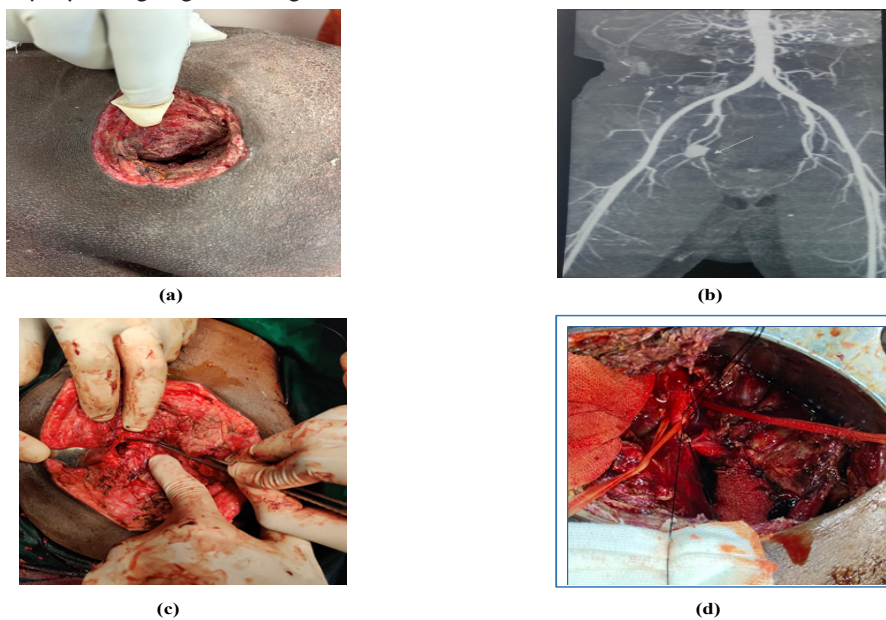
(a) Pulsatile swelling in right gluteal region. (b) CT angio : pseudoaneurysm in right inferior gluteal artery. (c) Haematoma evacuation. (d) Internal iliac artery ligation.
